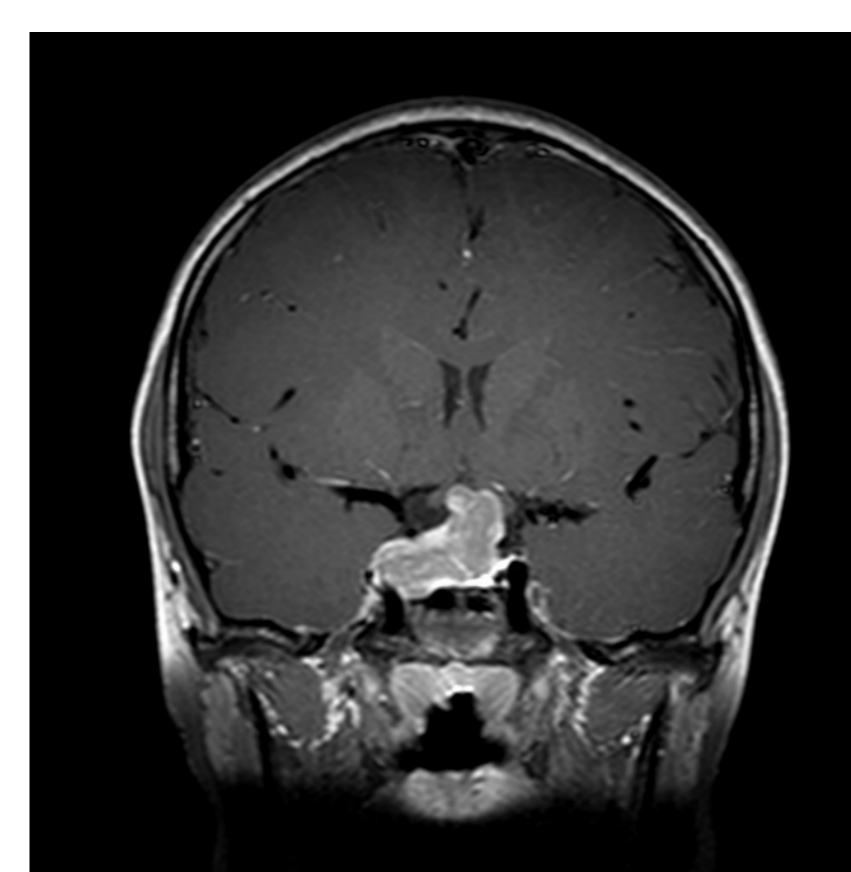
MRI, T1, before second neurosurgery
